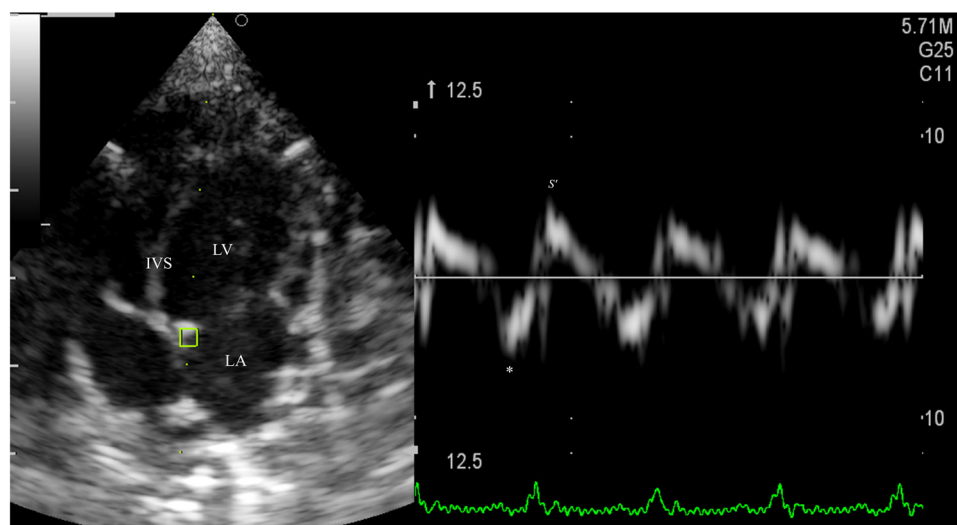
Showing parasternal long-axis apical 4-chamber view for measuring the spectral tissue Doppler imaging (TDI) at mitral annulus. LV = left ventricle; IVS = intraventricular septum; LA = left atrium; s' = systolic wave; * = fusion of early diastolic (e') and atrial contraction (a') velocities.
